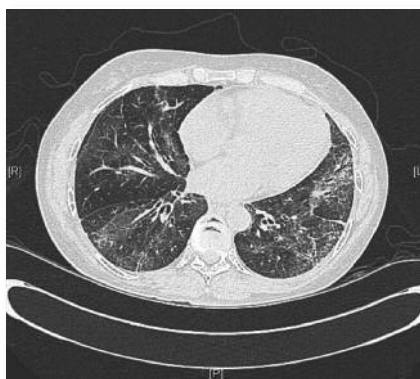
High-resolution CT scan showing interstitial lung disease with interstitial thickening, ground glass change, honeycombing and traction bronchiectasis.
